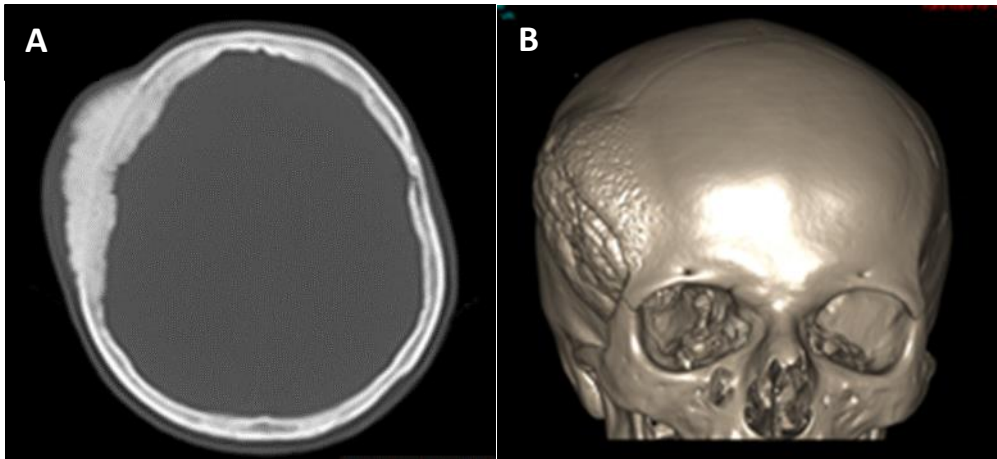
Axial CT scan (with bone window) showing (A) Hyperostosis and bone invasion in an intraosseous meningioma with (B) 3D reformats demonstrating a visible skull deformity arising secondary to the hyperostosis.
